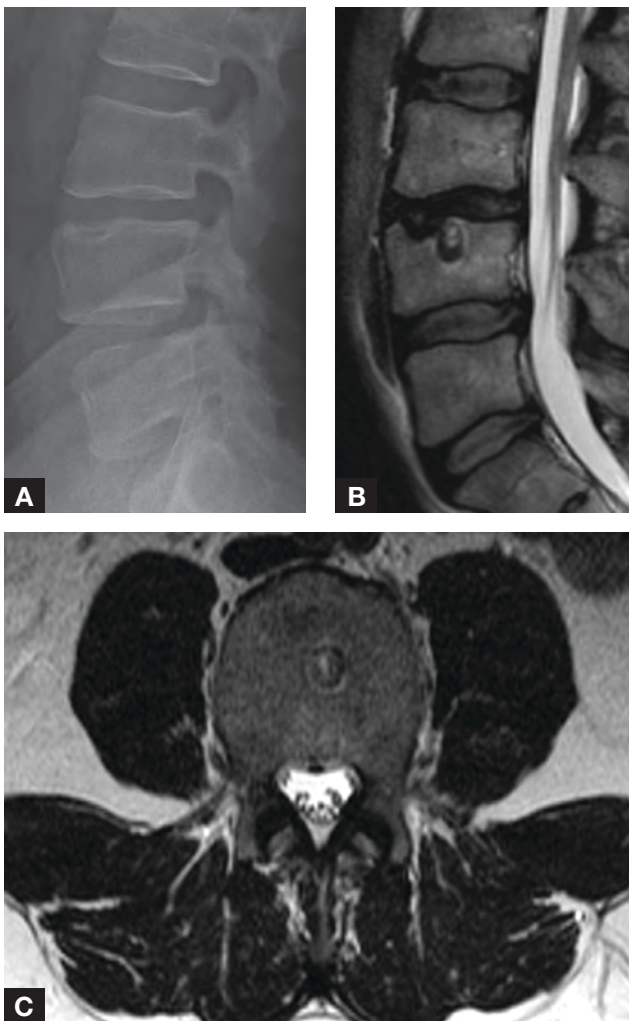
(A) Plain radiograph showing cystic radiolucency at anterosuperior endplate of L4. Sagittal (B) and axial (C) T2 MRI show disc material with L4 vertebral body and surrounding edematous changes.
